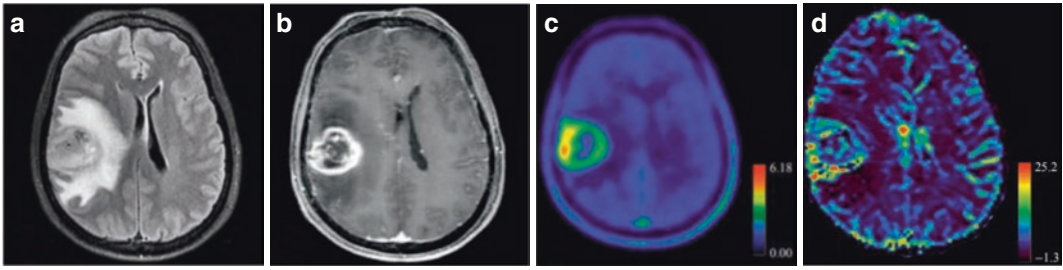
IDH-wildtype glioblastoma, WHO grade IV. A 53-year-old male patient, whose integrated PET/MR shows a round mass in the right parietal lobe. Transverse FLAIR shows heterogeneous mixed hyper- and hypointense signals with finger-like perilesional edema (a); contrast-enhanced scan shows a heterogeneous ring-enhancing
